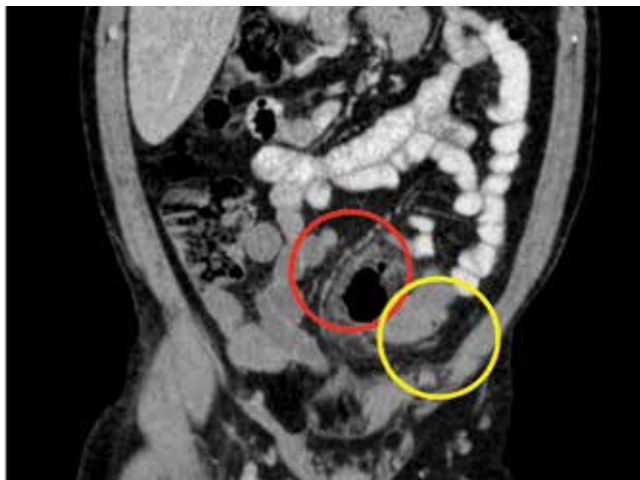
CT scan showing localised diverticular perforation with an abscess (red circle) and an adjacent segment of thickened sigmoid colon (yellow circle).
